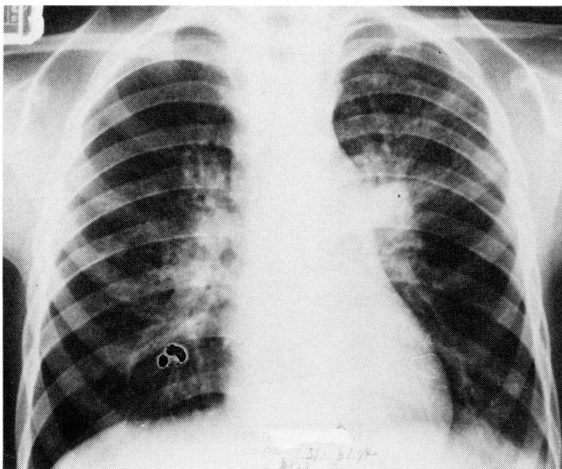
First chest X-ray film (Case 4).
